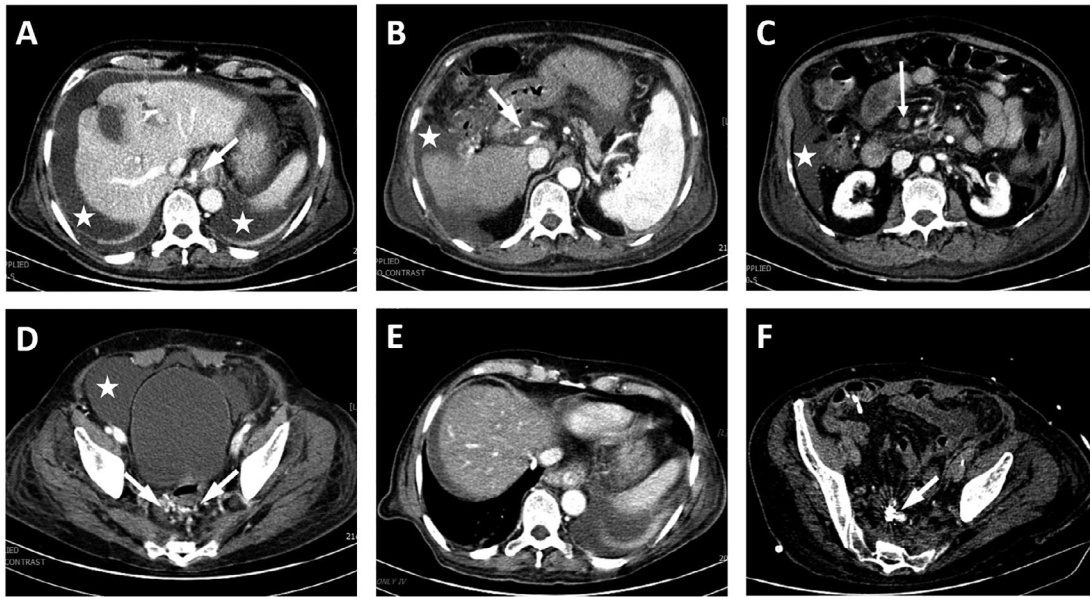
(A-D) Axial abdominopelvic CT images with iodinated contrast material 1 day before embolization. (A) Coronary vein and esophageal varices (*arrow*) appeared in gastrohepatic and paraesophageal spaces. (B) Portal vein partial thrombosis (*arrow*) and (C) complete superior mesenteric vein thrombosis were detected. (D) Dilated variceal veins were observed around the rectum and moderate ascites was noted in the abdominopelvic cavity (*asterisk*). (E-F) Follow-up study after 10 days. (E) Disappearance of esophageal varices is noted. (F) Rectal variceal obliteration and residual Lipiodol are seen.
